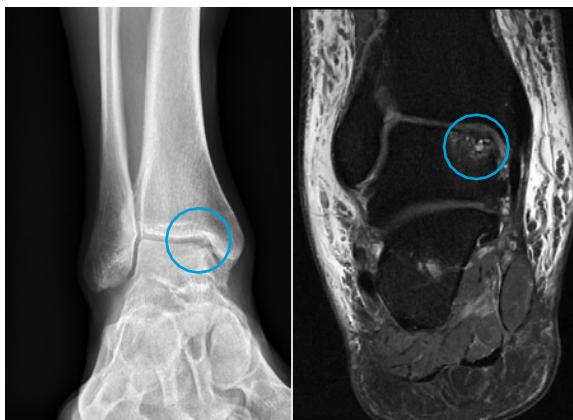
X-ray (left) and MRI (right) with osteochondral lesion on the talus
